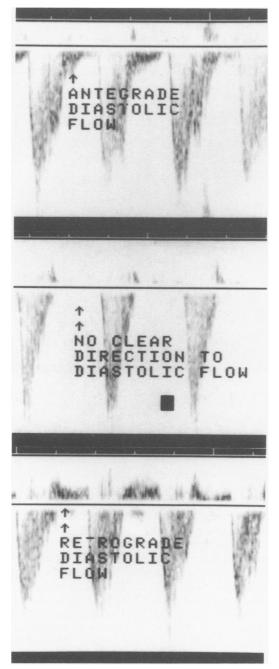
Post-ductal aortic Doppler. From a high right parasternal window the insertion of the ductus into the aorta is identified and the flow pattern beyond the insertion is recorded. The figure contrasts the normal antegrade diastolic flow seen with a closed or small PDA (top) with the absent diastolic flow seen with a moderate PDA (middle) and the retrograde diastolic flow seen with a large PDA. The ductus was patent in all examples shown here. The diameters were (from top to bottom) 1.1 mm, 1.7 mm, and 2.5 mm (reprinted with kind permission of Mosby Year Book Inc⁹).
